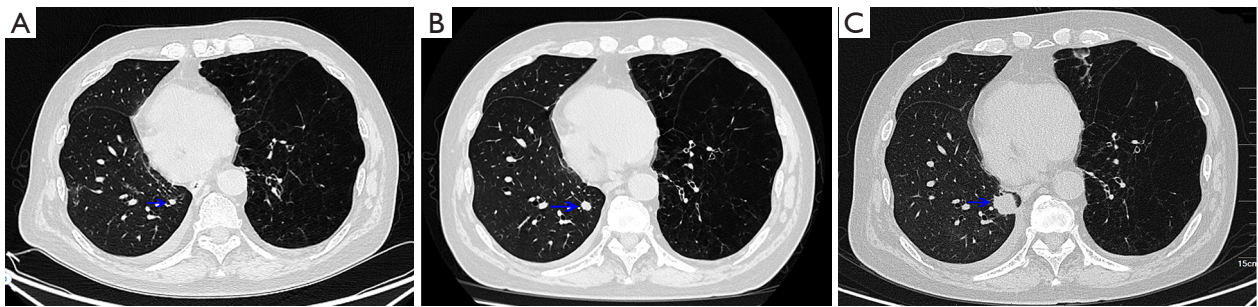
A timeline chart for chest CT. (A) One year after lung transplantation, a chest CT scan revealed a small solid nodule with a diameter of ~0.5 cm in the posterior basal segment of the right lower lung (blue arrow). (B) Three months later, the pulmonary nodule increased to a diameter of 1 cm after 3 months (blue arrow). (C) Four and a half months later, chest CT showed an enlarged pulmonary nodule ~2.5 cm in diameter with shallow lobulation, short hair spurs on the edge and the presence of pleural traction (blue arrow). CT, computed tomography.
